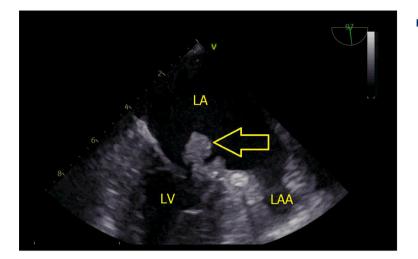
Transesophageal echocardiography. Vegetations of the mitral valve (indicated by yellow arrow). The image was acquired using a VIVID5S, General Electrics phased array ultrasonoscope (Tirat Carmel, Israel). LV – left ventricle; LA – left atrium.
